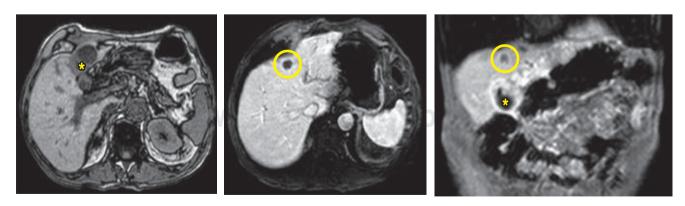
A MRI cholangiography showing findings compatible with locally advanced gallbladder neoplasia (asterisk) and metastatic lesion in hepatic segment IVb (circle).
